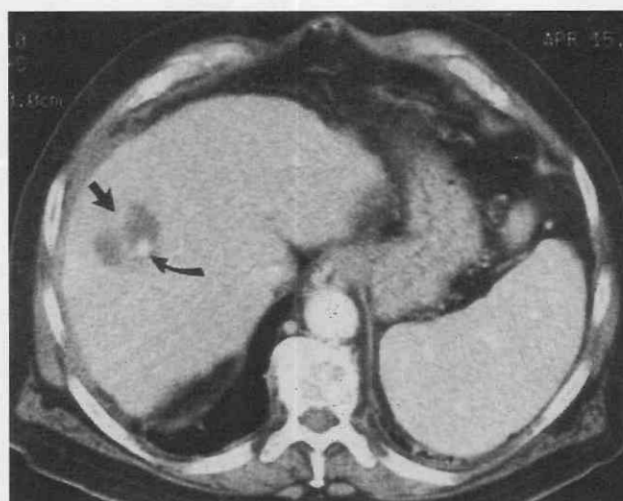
Hepatocellular carcinoma in a 70-year-old man with a cirrhotic liver. Contrast-enhanced CT scan demonstrates a predominantly low-attenuation mass with enhancement of the non-necrotic area of the tumor (straight arrow). An enhancing vessel (curved arrow) is well demonstrated on this dynamic bolus-enhanced scan. A rim of ascites is present.
